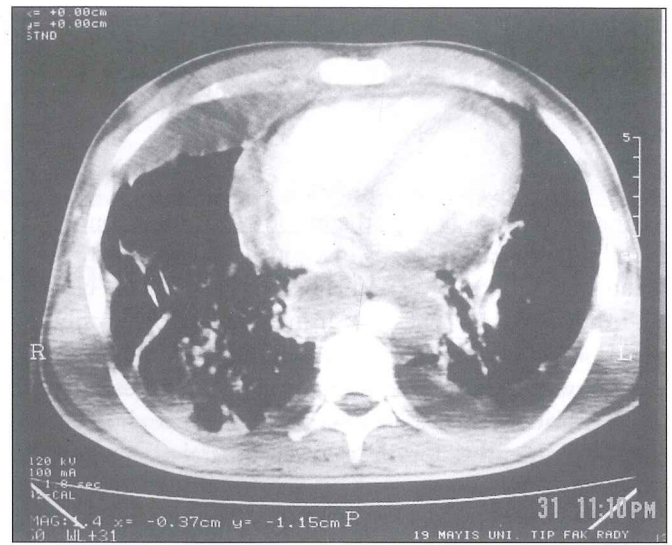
Preoperative thoracic CT showing posterior mediastinal abscess and bilateral pleural effusion.
